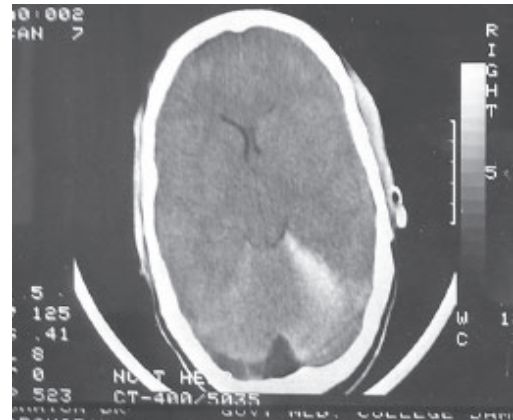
CT showing tentorial ISDH
